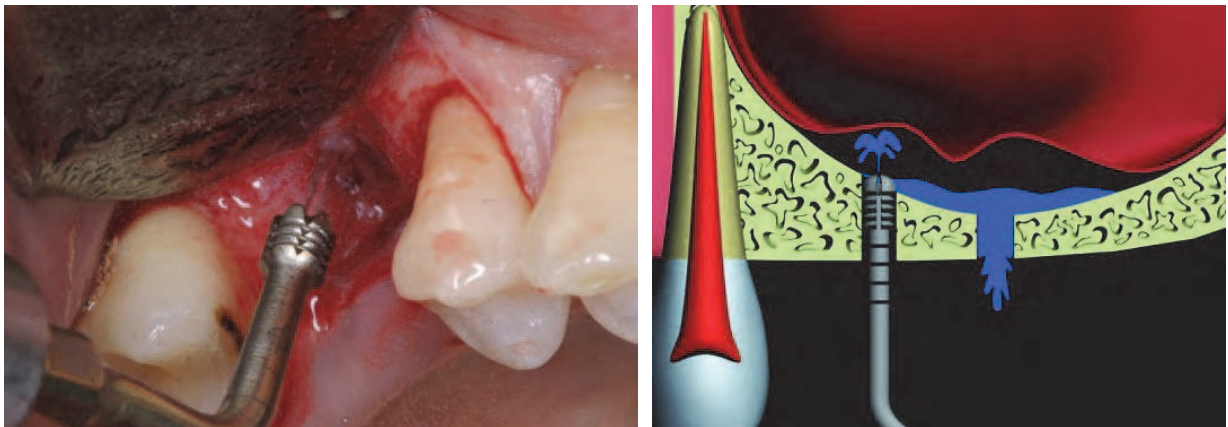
(left) and Fig. 39. (right). HPISE is inserted to break sinus floor using ultrasonic vibration and elevate sinus membrane using water pressure.
